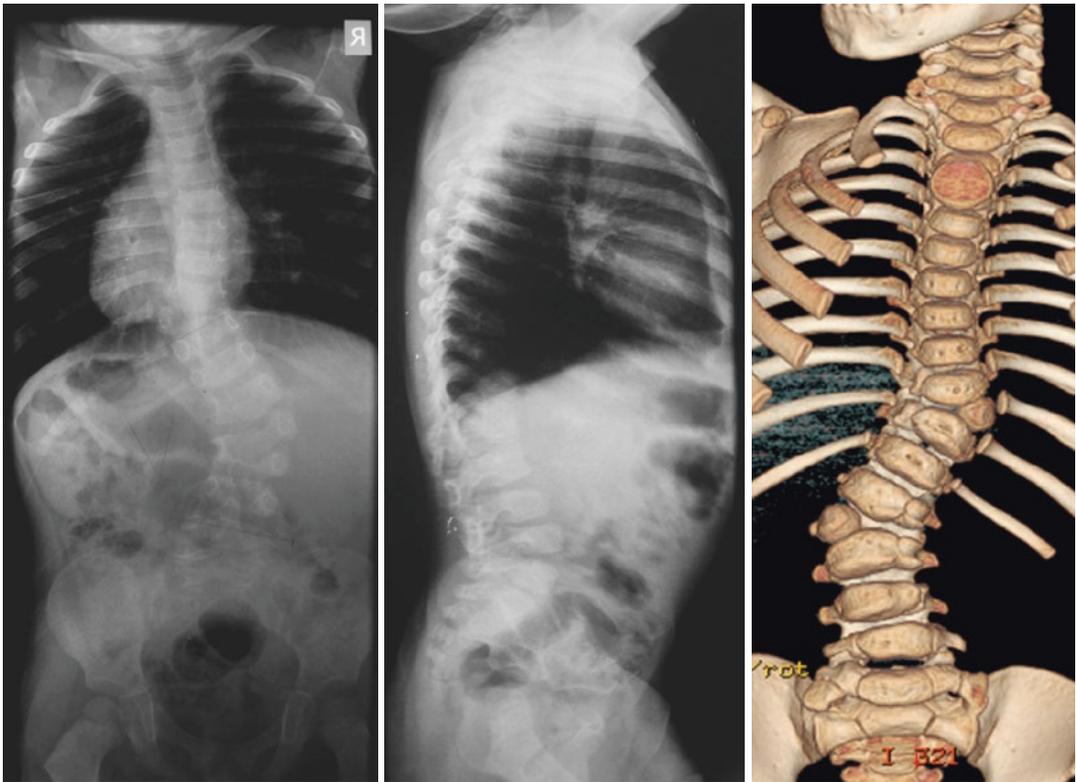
P-A and Lateral long cassette X-ray and 3D reformatted CT scan (c) of the patient show contralateral hemivertebrae at T10 and L2 levels
